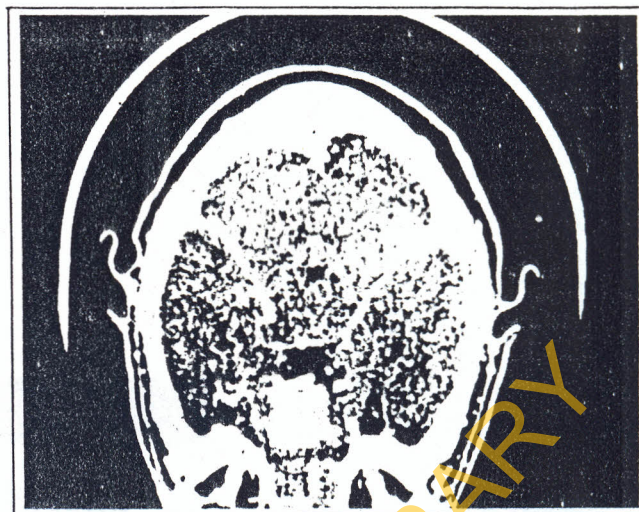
Fig III CT Scan of the patient with a suprasellar mass.
